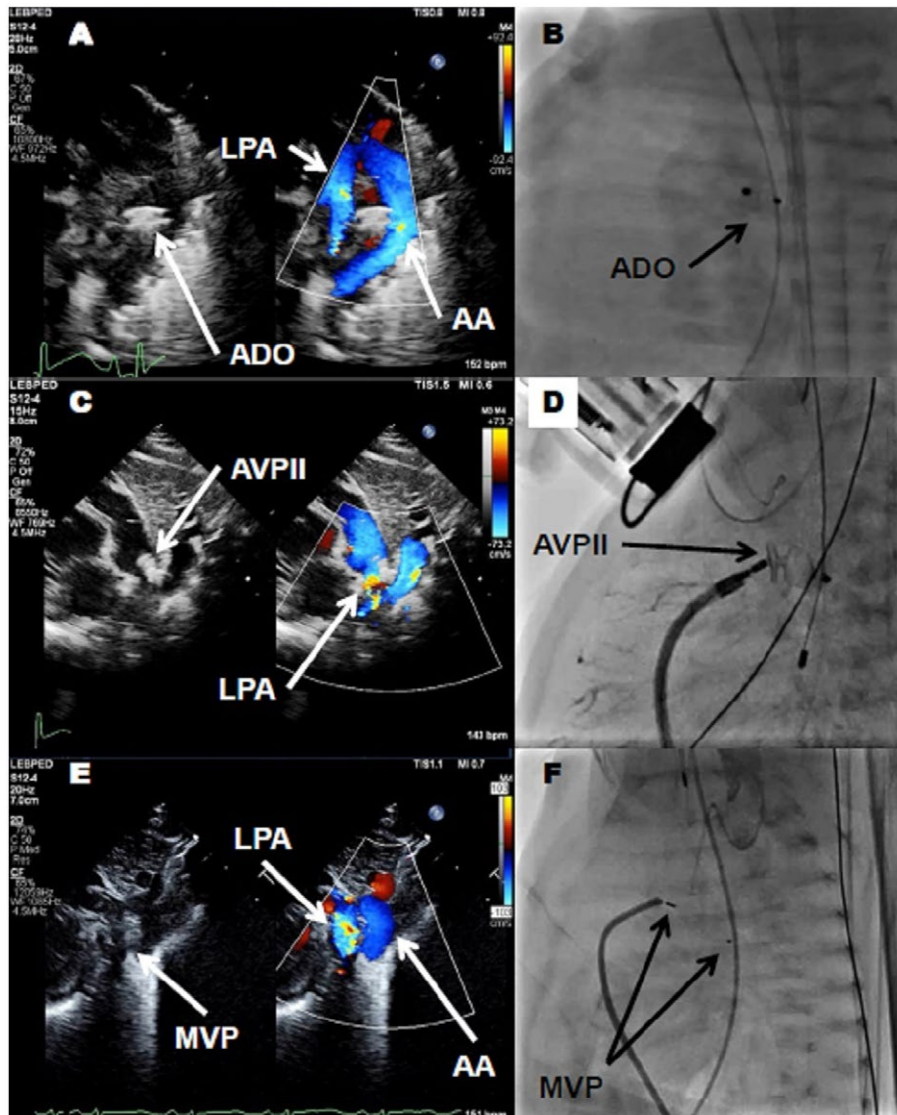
High left parasternal transthoracic echocardiogram color Doppler and lateral angiogram of different transcatheter PDA devices. Amplatzer Duct Occluder (ADO). Amplatzer Vascular Plug II (AVPII). Aortic arch (AA). Left pulmonary artery (LPA). Micro Vascular Plug (MVP)
